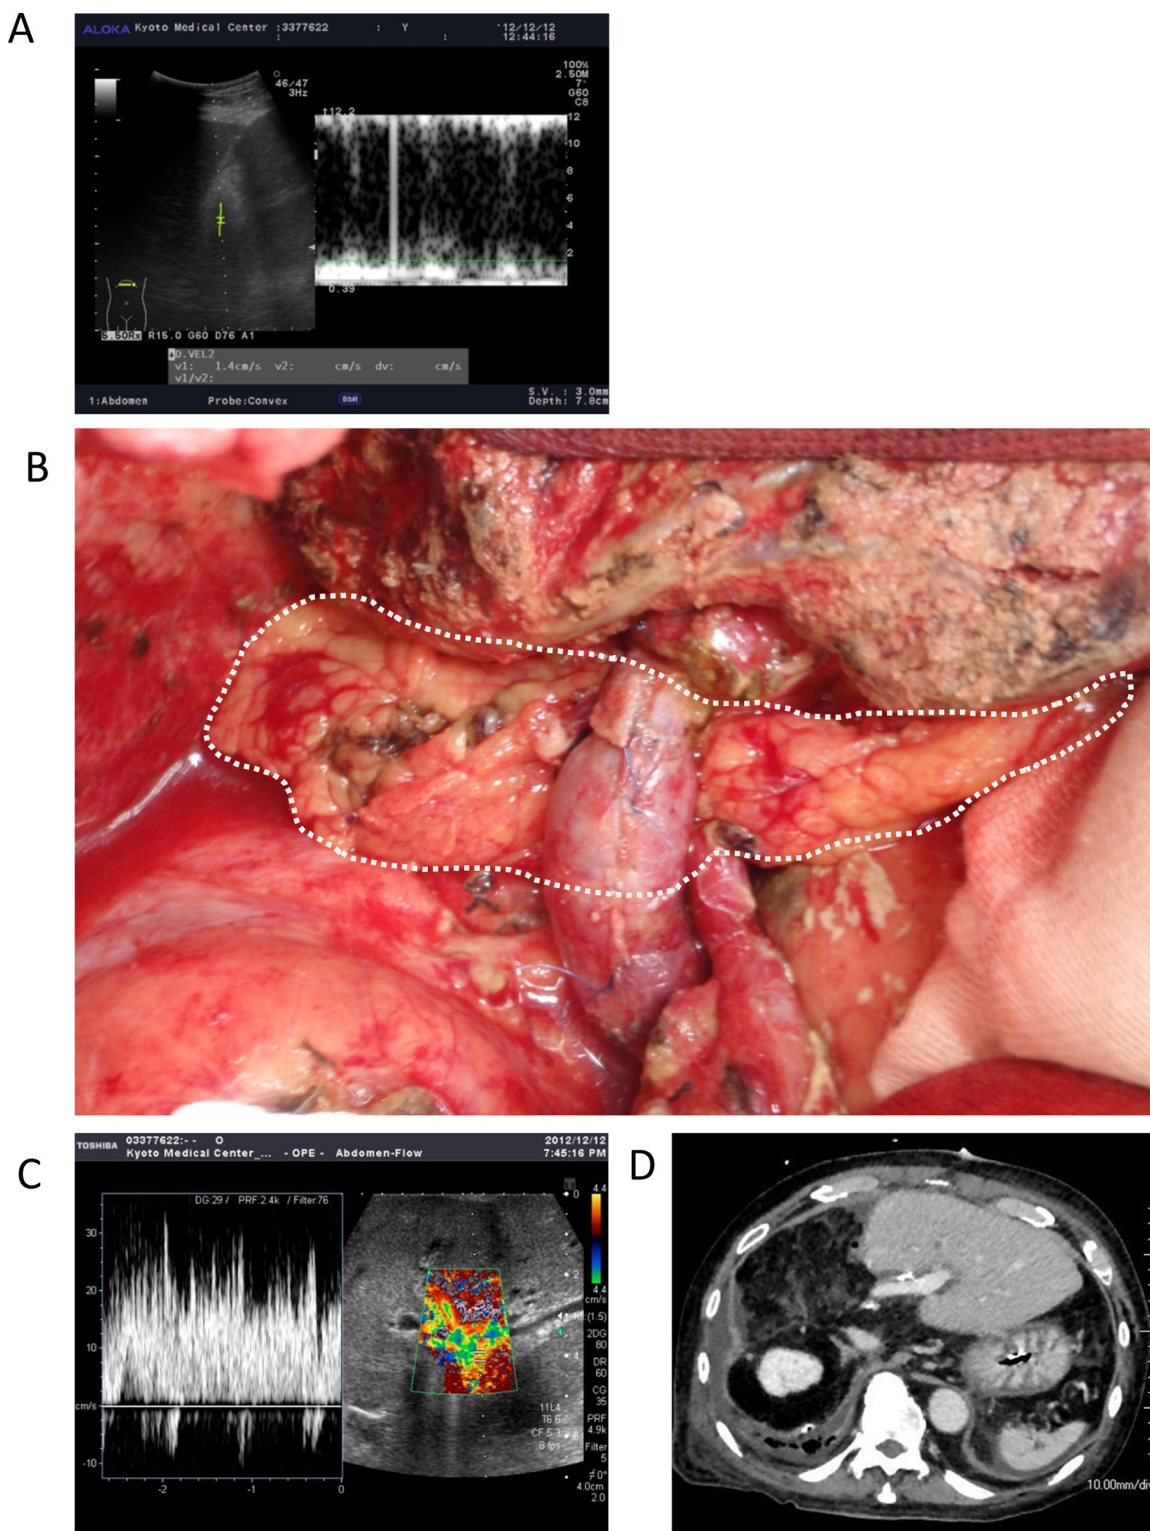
Doppler US and CT imaging study and intraoperative photography at the relaparotomy in the case 1. (A) Doppler US at postoperative day (POD) 1 shows significant decrease of portal flow velocity. (B) Intraoperative photograph represents the main trunk of portal vein following removal of portal venous thrombosis and vascular reconstruction. Dotted line indicates the pedicled omental transposition flap placed between portal vein and inferior vena cava to fill in the dead space. (C) Intraoperative Doppler US shows favorable intrahepatic portal blood flow. (D) CT scan at POD 7 shows the patency of portal vein.
